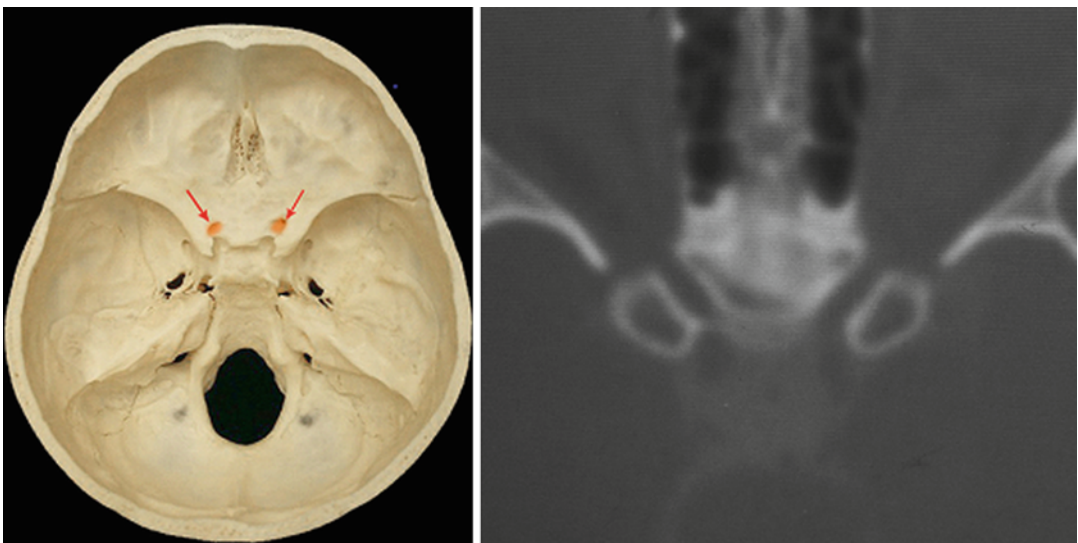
Anatomy of the optic canals. *Left*, direction of the canals from anterolateral to posteromedial. *Right*, axial CT scan showing the canals
